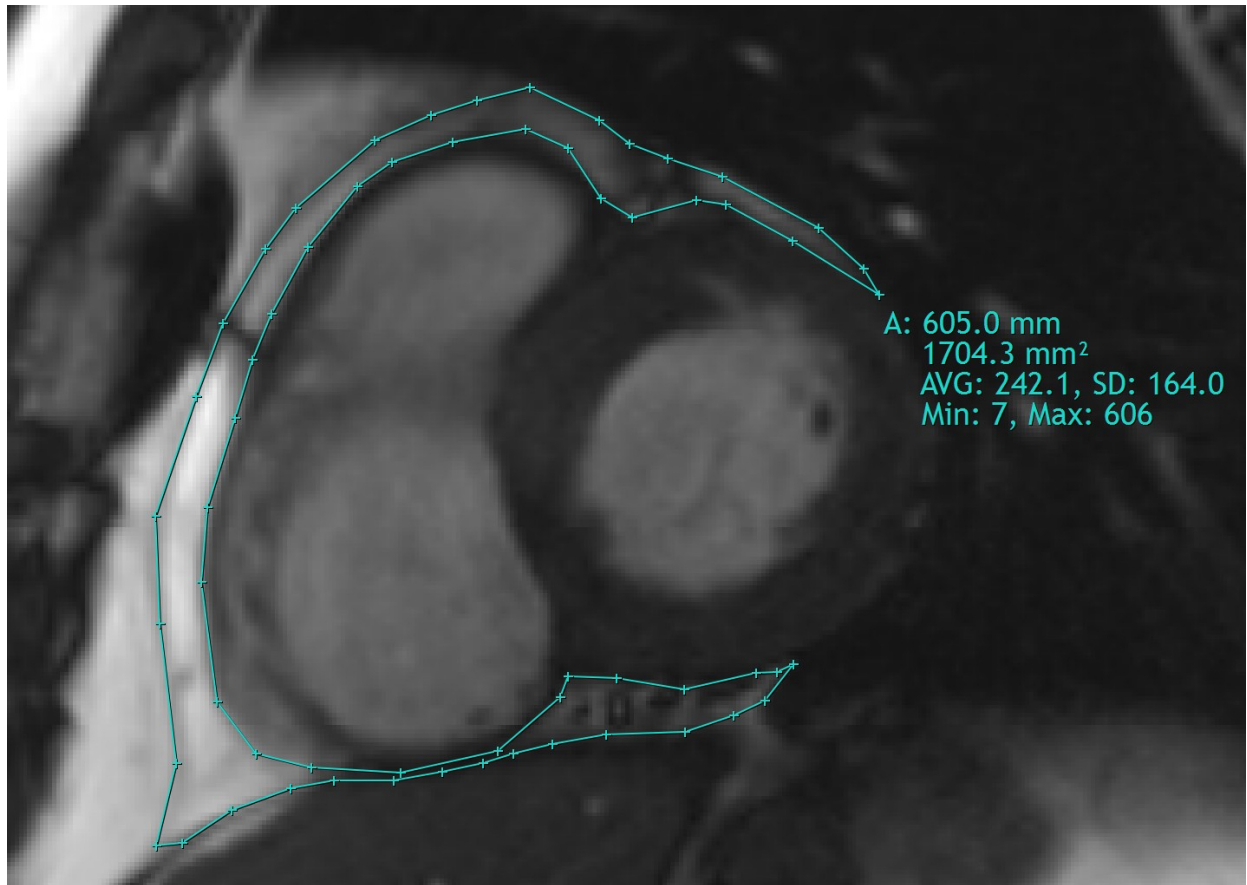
Measurement of EAT area using end diastolic short-axis cardiac magnetic resonance images (for the calculation of EAT volume)
